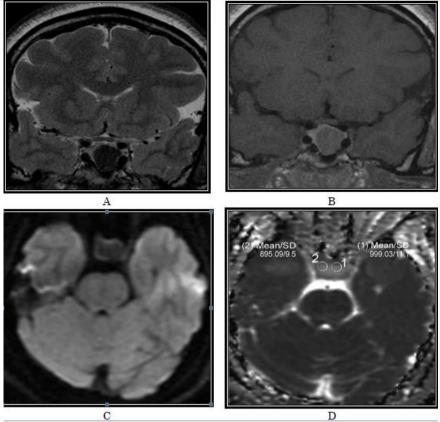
A- Coronal T2WI revealed hypointense sellar & supra sellar lesion. B- Coronal T1WI Post Gd DTPA revealed homogeneous enhancement of the lesion. C- Axial DWI displayed hypointensity of the lesion which is consistent with unrestricted diffusion. D- ADC map revealed hyperintensity of the lesion with ADC value $0.94 \times 10^{-3} \text{ mm}^2/\text{s}$.
